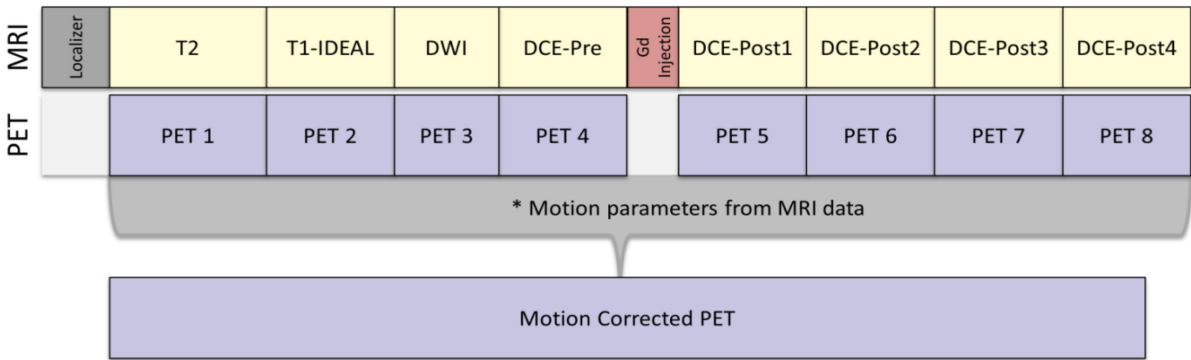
Simultaneous acquisition of PET events during the acquisition of the MRI sequences. PET data will be segmented and motion corrected corresponding to the anatomic position as determined by the MRI sequence coinciding with the PET data acquisition.
